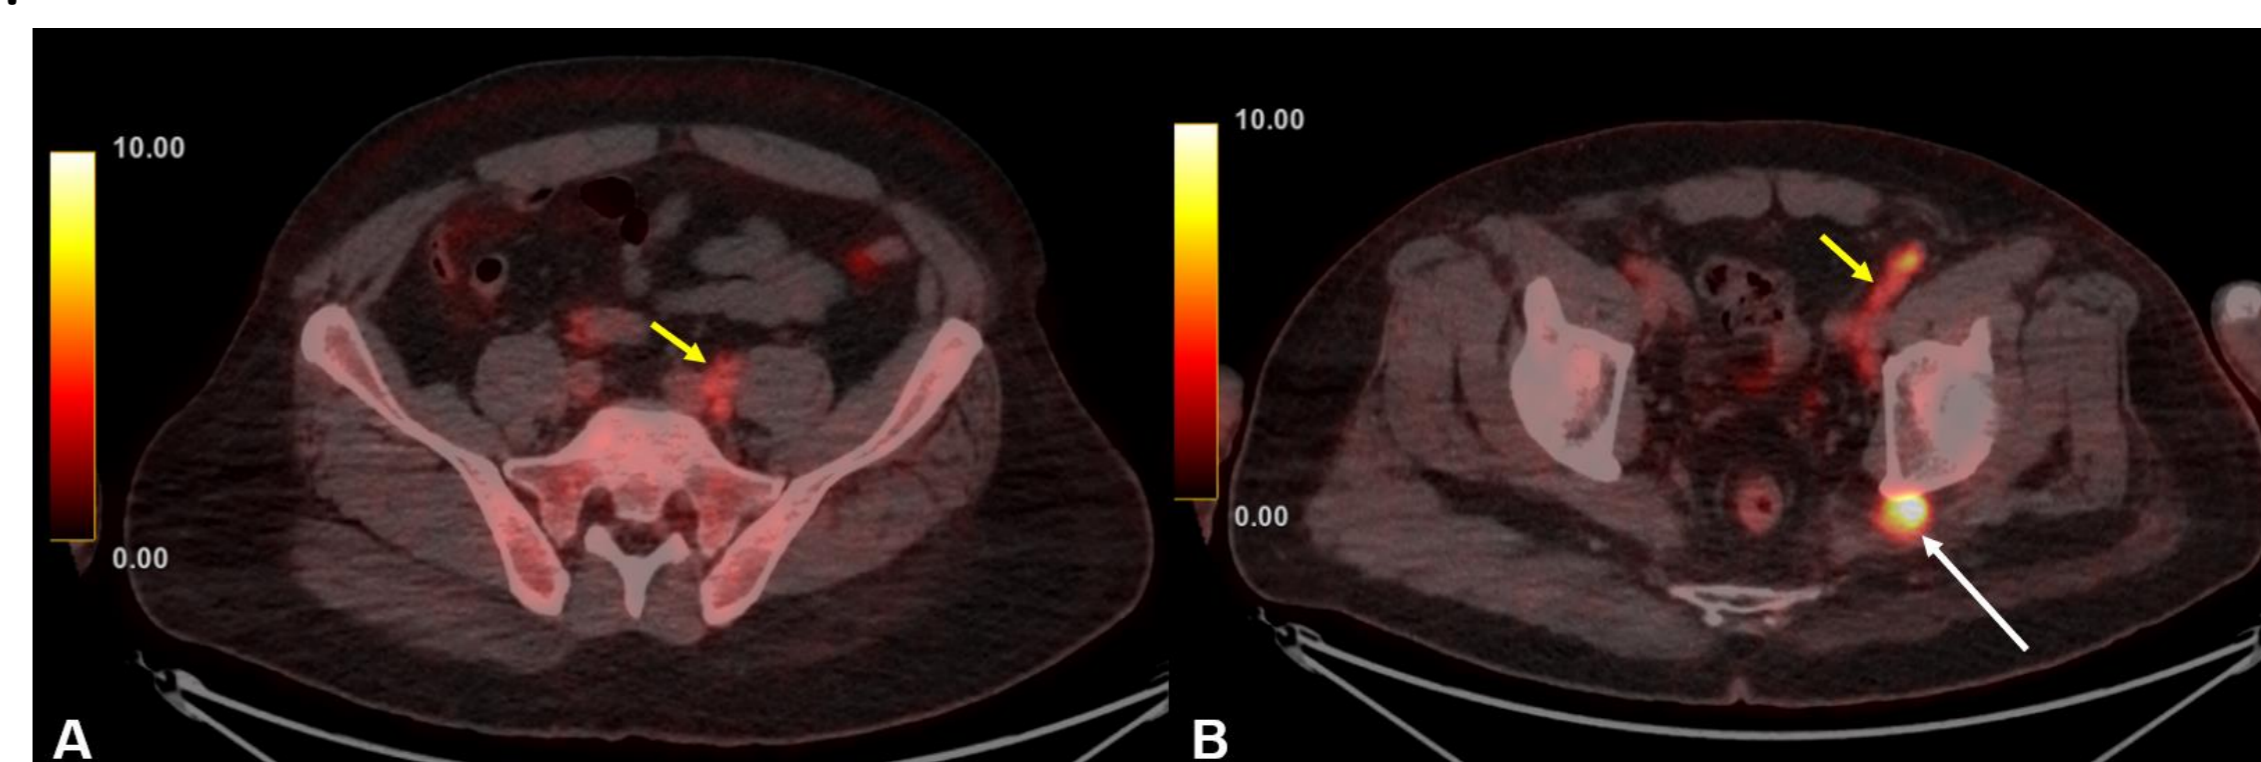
Torso PET-CT (FDG) demonstrates multiple hypermetabolic lymph nodes along the left ilioinguinal chain (A, B), as indicated by the yellow arrows, and a hypermetabolic lesion posterior to the left posterior acetabulum (B), indicated by the white arrow, suggesting sciatic nerve involvement.
